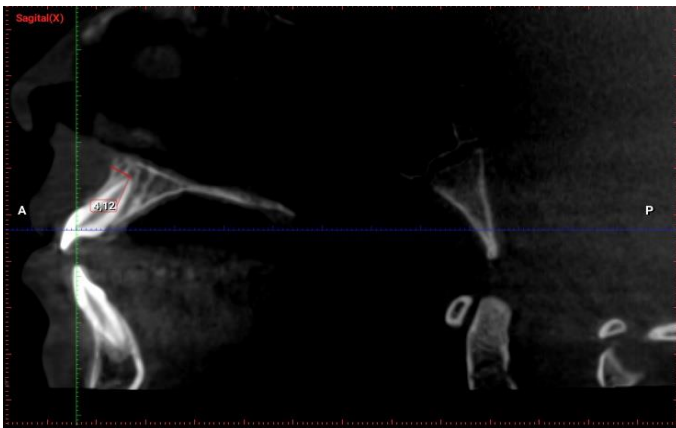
Measurement of the distance of the maxillary central teeth to the nasopalatine canal in the axial plane on CBCT.
